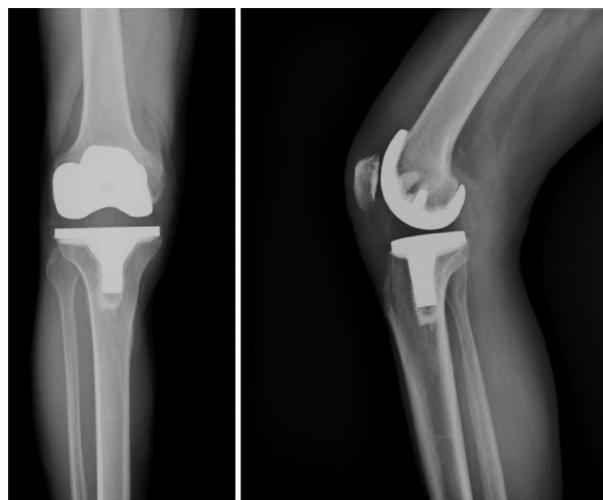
Three months postoperative radiograph could be obtained in proper alignment.
